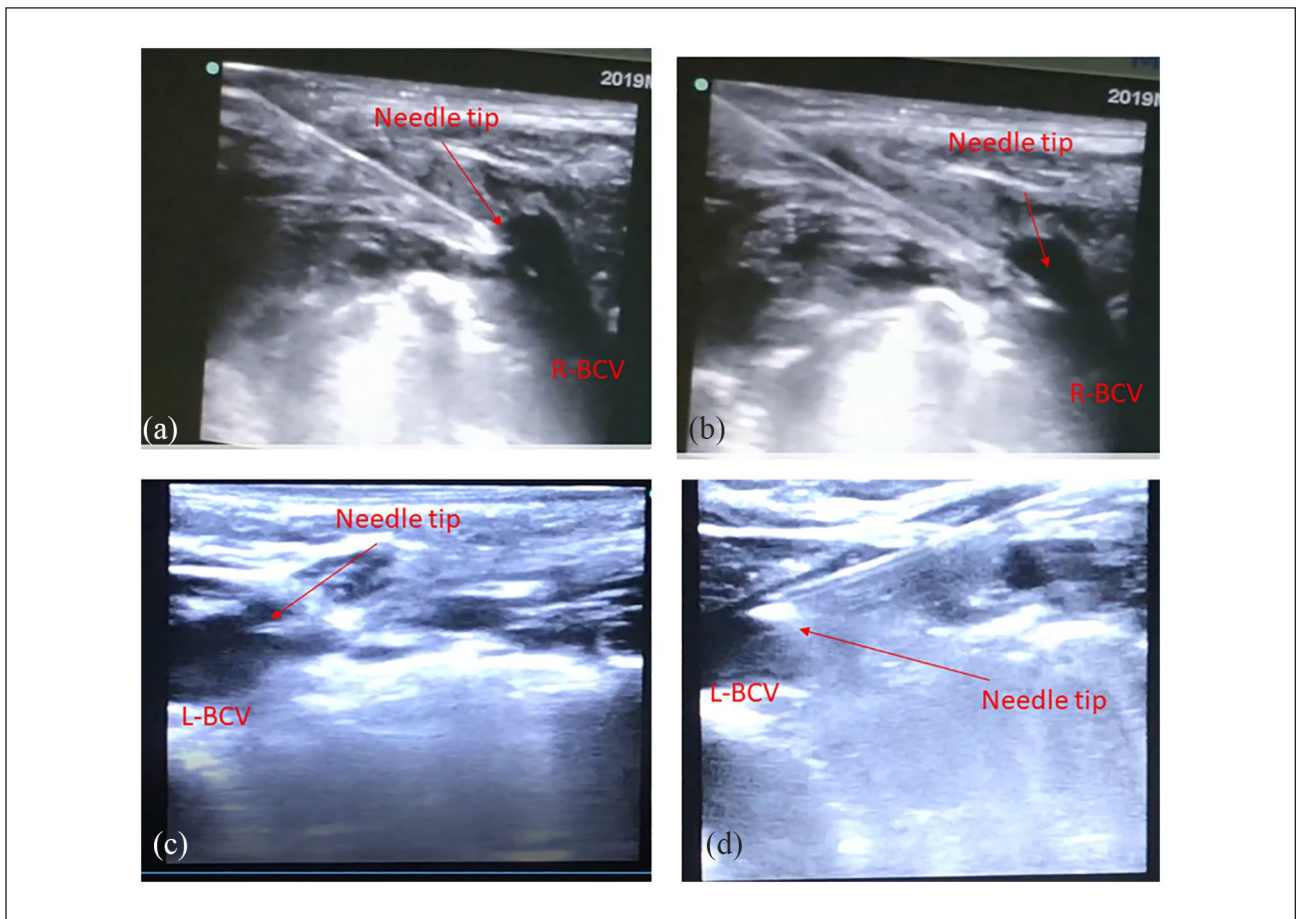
Figure 3 shows the ultrasound image showing the puncture needle (not the guidewire) inside the BCV in two very low-weight babies. (a) Needle tip clearly visualized at the wall of the right BCV vein in a preterm infant of 650 g. (b) Needle tip advanced into the vein. (c) Needle tip at the wall of the left BCV vein in a preterm infant of 580 g. (d) Needle tip advanced into the vein.
